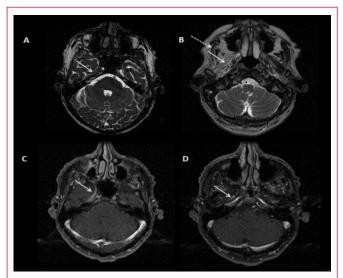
A) MRI axial T2 demonstrates obliteration of Meckel's cave (white arrow) by tumor. B) MRI axial T2 depicts the replacement normal pterygoid muscles by fat (white arrow) secondary to denervation of muscle by perineural involvement of CN V3. There has been atrophy of the masseter muscle (dashed arrow) when compared to the contralateral side. C) MRI axial T2 sequence highlights the infiltration of foramen ovale (white arrow) by perineural involvement of CN V2. D) MRI axial T2 sequence inferior to that shown in C shows the infiltration of foramen rotundum by tumor involvement (white arrow) of CN V3.
